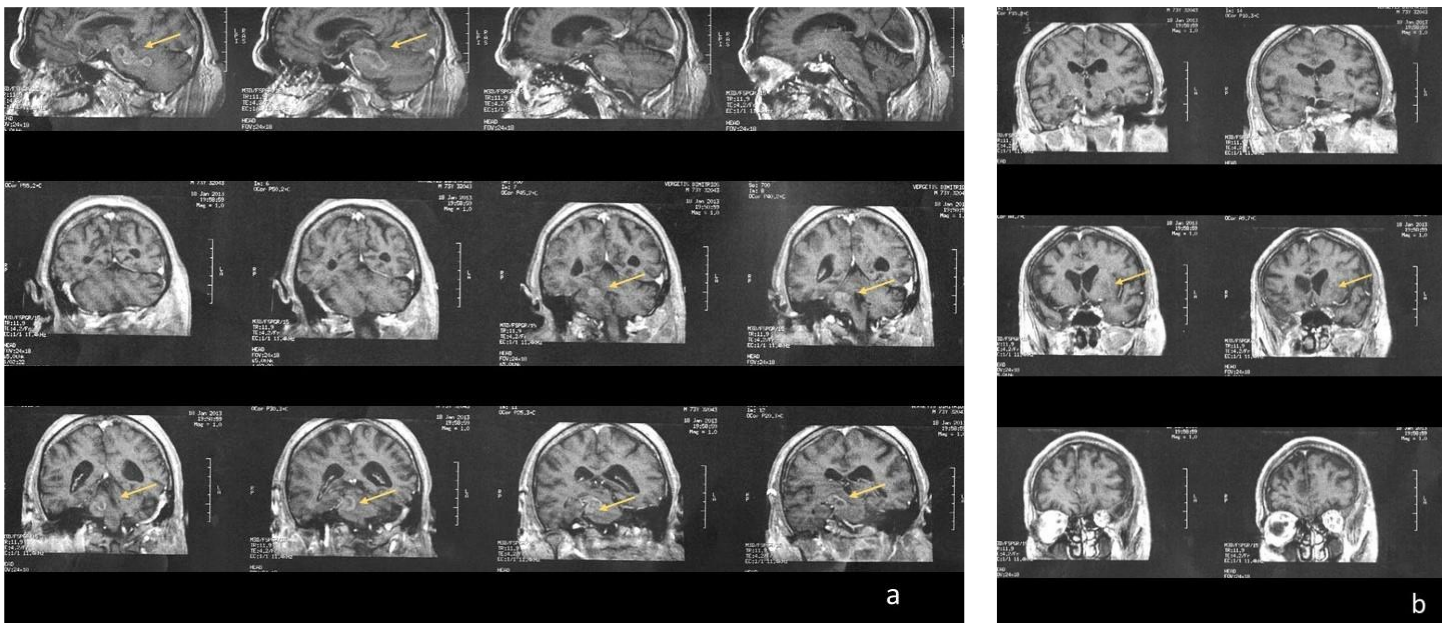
Computed tomography demonstrated a) two brain metastases (depicted by yellow arrows) at the level of midbrain and b) two brain metastases (depicted by yellow arrows) at the basal ganglia.
